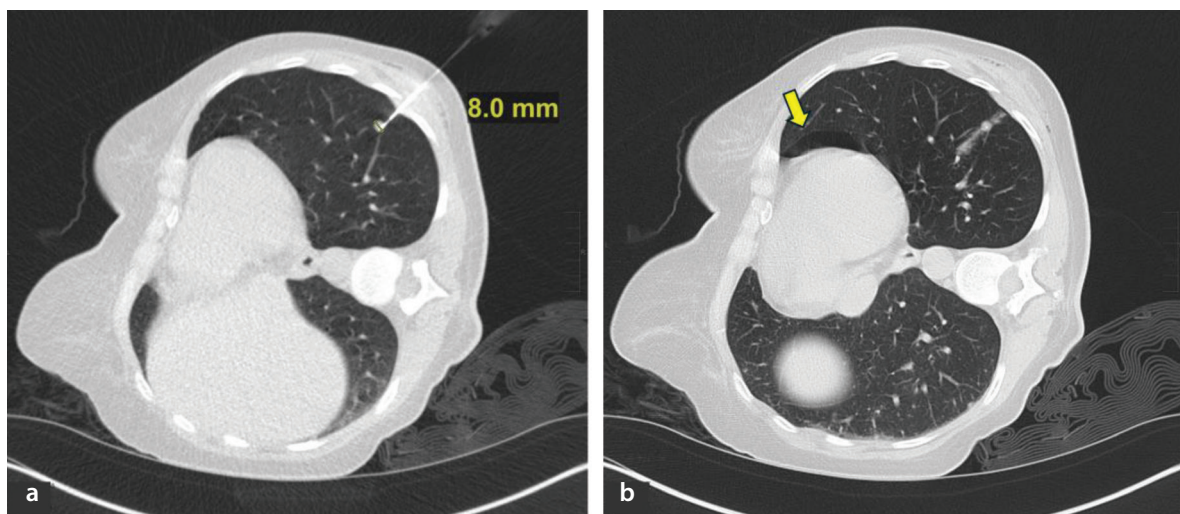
Computed tomography (CT) fluoroscopy-guided lung biopsy of an 8 mm nodule in the left lower lobe in a female patient with suspected recurrence of ovarian carcinoma. (a) Fluoroscopic image during the procedure, performed with the patient in the right lateral decubitus position using an 18G semi-automatic spring-loaded cutting needle system. (b) Post-procedural CT scan showing minor hemorrhage at the puncture site and a small ventral pneumothorax (yellow arrow), both of which were successfully managed conservatively.
